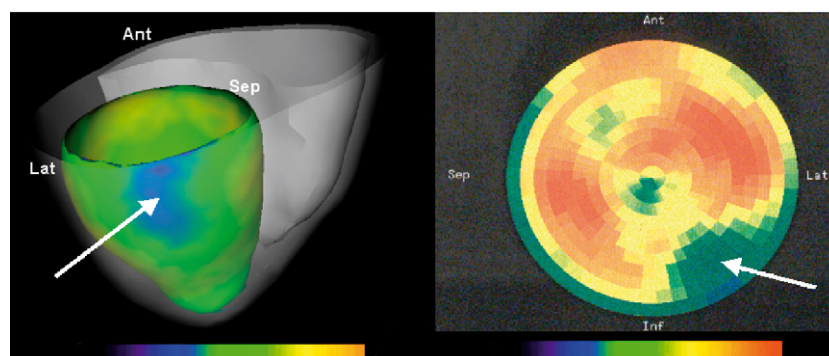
3-D representation of the FDG PET uptake values on the biventricular heart model (left) for patient P1. Interactively made bull's eye representation (Siemens software) of the corresponding PET image is presented on the right. The polarmap shows PET values at mid-wall location. Scar area can be seen in dark green at the basal level of the 3-D display (arrows).
